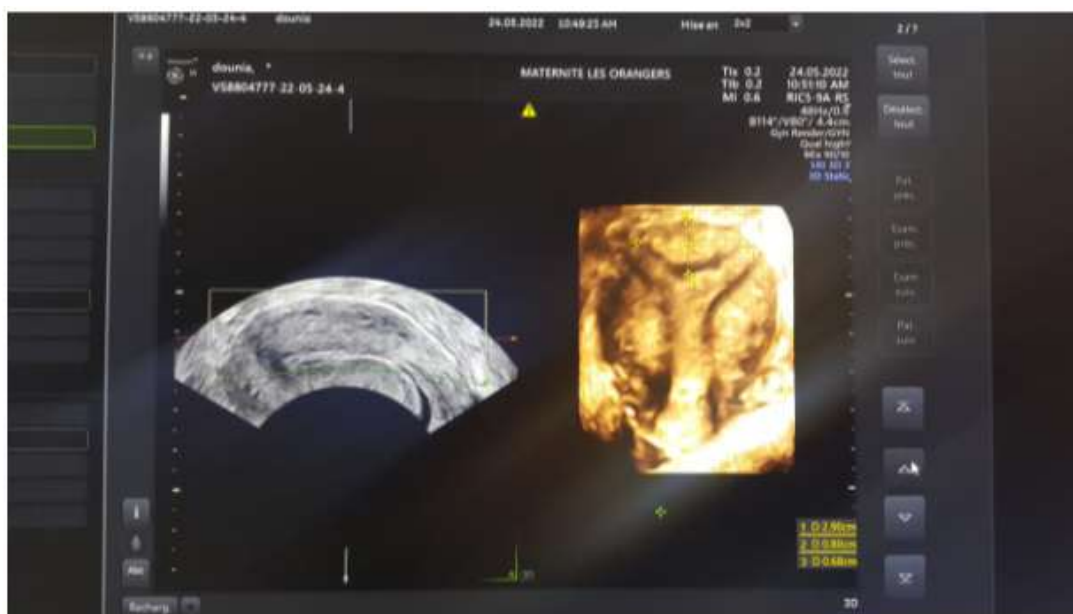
Comparison between images of a 2D and 3D uterine ultrasound.
